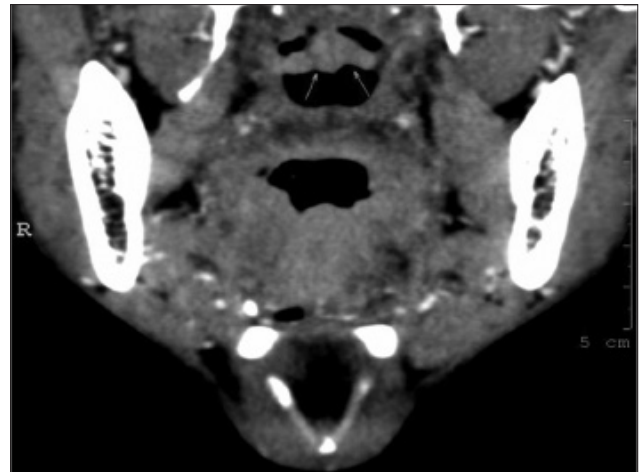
MRI coronal view showing narrowing of the oropharynx due to the membrane (shown by arrow)
